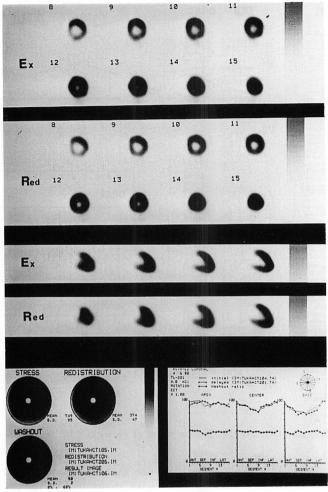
Stress thallium scan (SPECT) of the patients in Fig 4.
